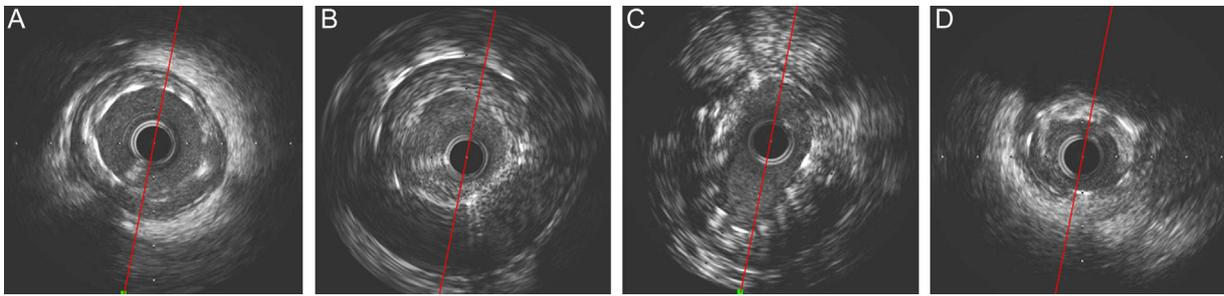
Qualitative intravascular ultrasound findings. A: malapposition. B: malapposition + aneurysm. C: underexpansion. D: calcified neoatherosclerosis plaque.
